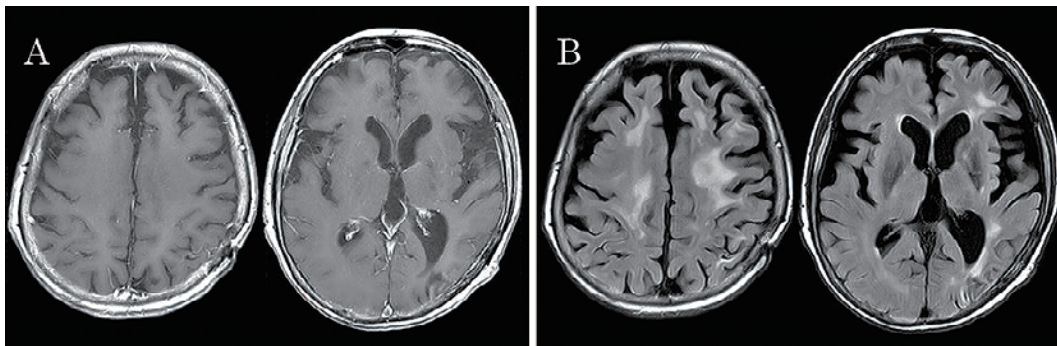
Brain MRI findings after 7 cycles of chemotherapy with R-MPV and rdWBRT.
